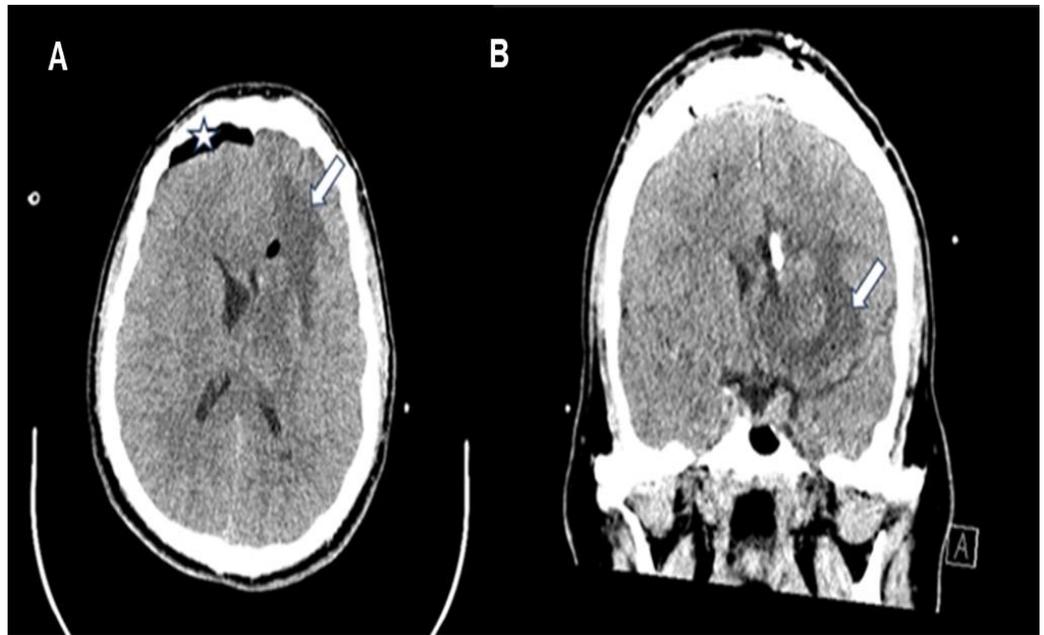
A Axial unenhanced CT brain post craniotomy with brain oedema (white arrow), with effacement of the left lateral ventricle and midline shift. Right frontal Pneumocephalus (Astrex) and within the left ventricle. B Coronal reformat unenhanced CT brain showing post craniotomy changes and left parietal oedema (white arrow). External Ventricular Drain partially seen.
